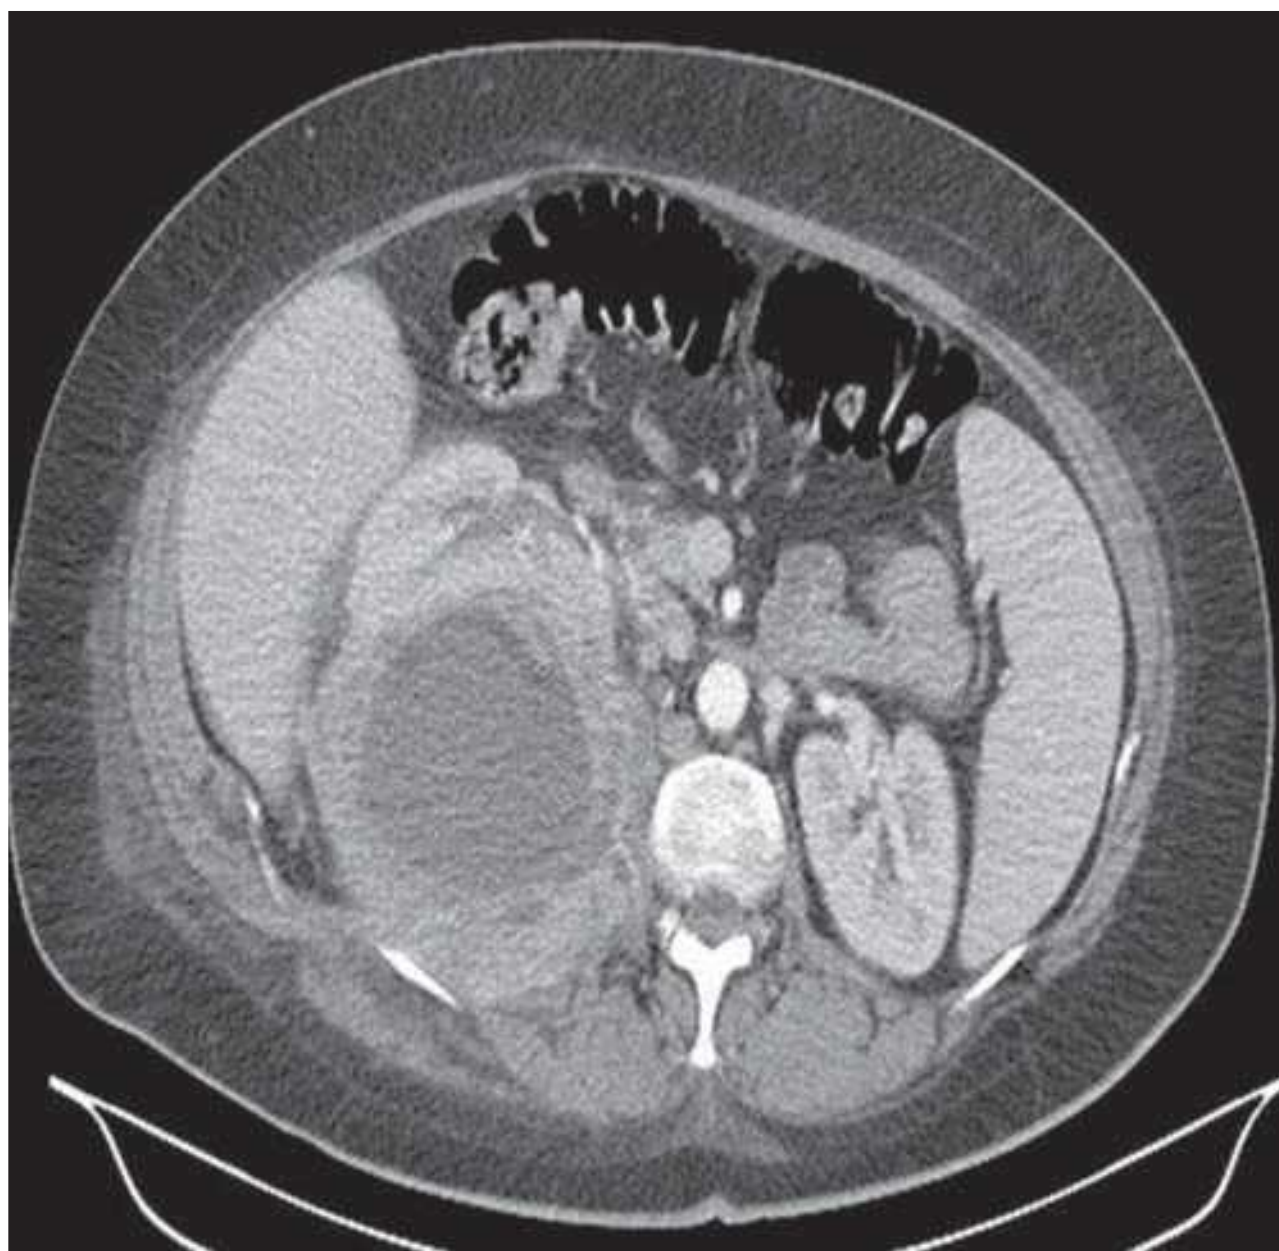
Contrast-enhanced CT showing a large, thick-walled abscess arising from the posterior cortex of the right kidney and extending into the adjacent posterior pararenal space.
